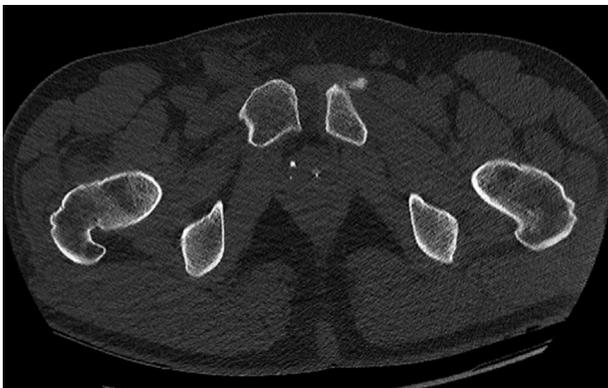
Axial CT of the pelvis in Grade I anteroposterior compression injury: pubic diastasis evident on follow-up CT without binder.
